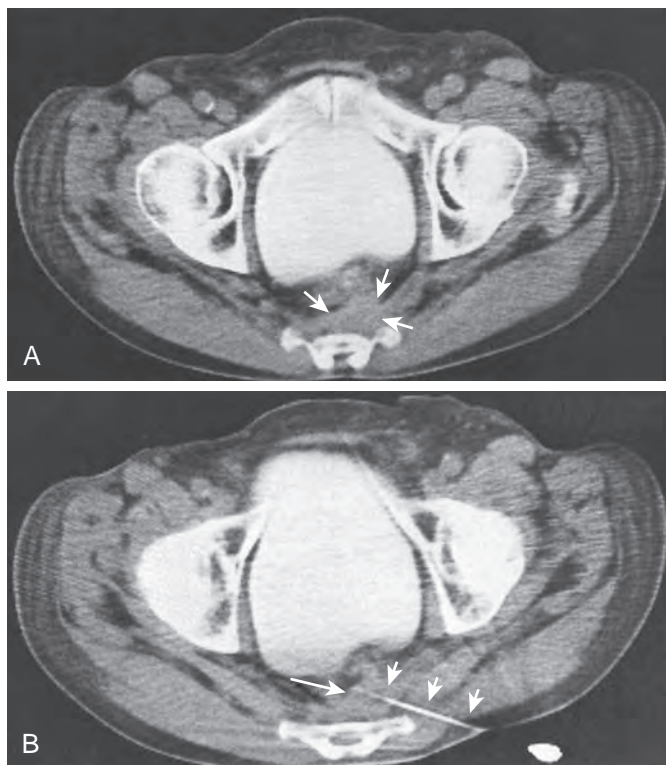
CT scan of recurrent rectal mass in patient after total abdominoperineal resection. A. Irregular soft tissue mass (arrows) is identified in the rectal bed. Size of mass has increased slightly compared with baseline CT study obtained 1 year before present examination. B. Percutaneous biopsy confirms presence of recurrent tumor. Short arrows outline the needle, with its tip in the mass of recurrent tumor (arrow).
